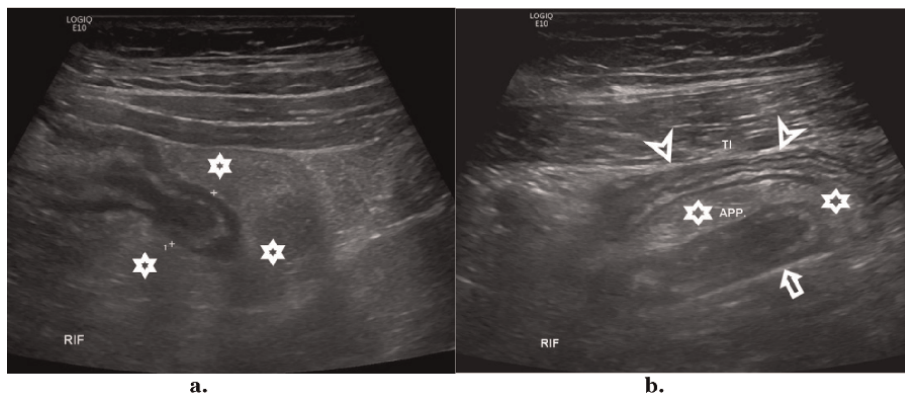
Uncomplicated appendicitis sonograms acquired from different patients. A: Shows the inflamed appendix (between callipers) measuring 10 mm (MOD) from serosa to serosa (S2S), also note the echogenic periappendiceal mesenteric fat wrapping/mesenteric oedema (stars) around the inflamed appendix. b: Shows an inflamed appendix (APP., arrow) in a longitudinal orientation with mild periappendiceal mesenteric oedema (stars) and normal terminal ileum (TI, arrow heads) seen coursing anterior to the appendix from the distal ileum towards the caecum in the RIF (not imaged).*
